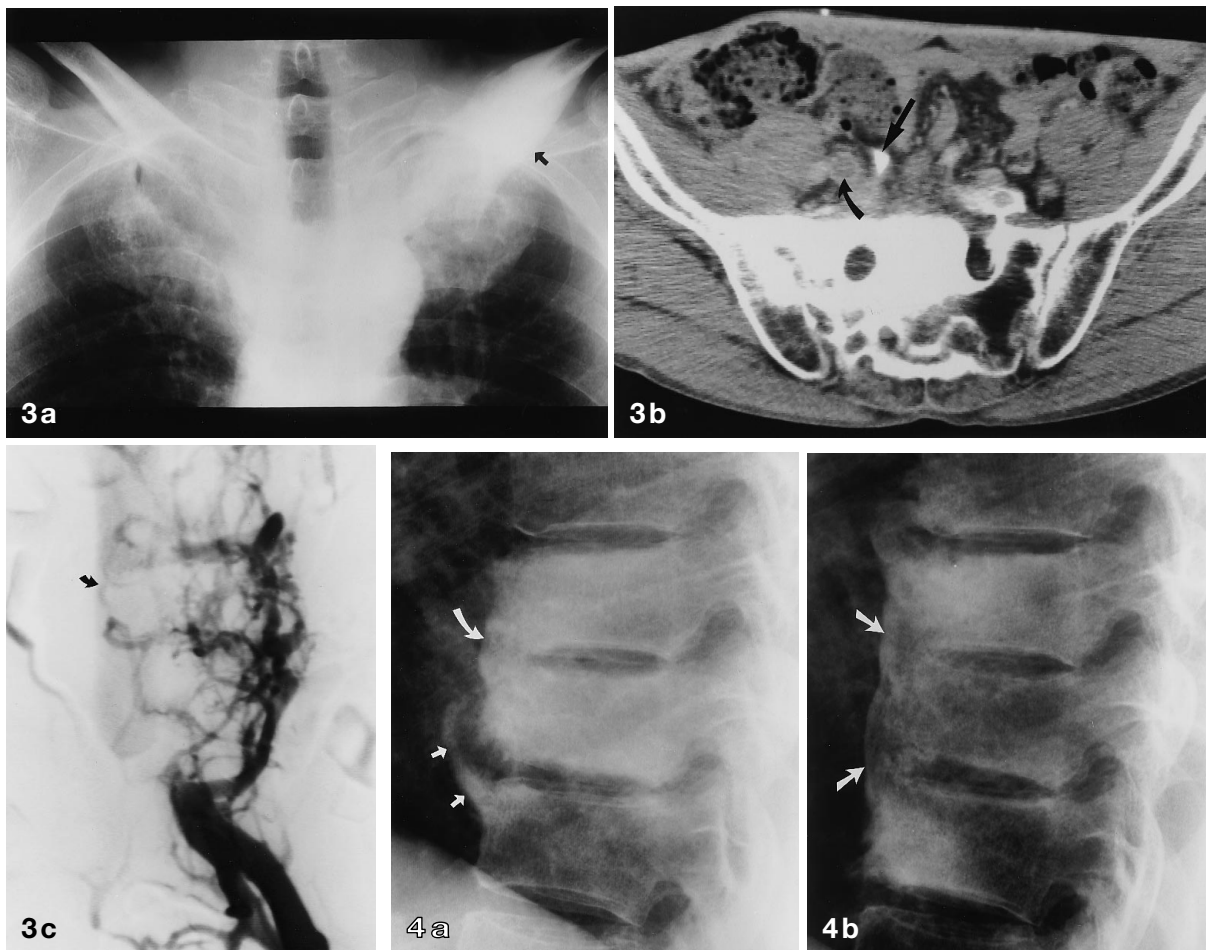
A 53-year-old man with PPP. a Posteroanterior radiograph of the chest shows hyperostosis (SCCH) of the anterior chest wall. Note the extensive periosteal reaction in the left clavicle (*arrow*). b Computed tomograph of the sacroiliac joints shows unilateral sacroiliitis. A soft tissue mass has displaced the right common iliac artery (*arrow*), and the right common iliac vein is thrombosed (*curved arrow*). c Inferior venacavogram injected through the left femoral vein reveals complete obstruction of the inferior vena cava (IVC). The proximal portion of the IVC is faintly opacified (*arrow*)
